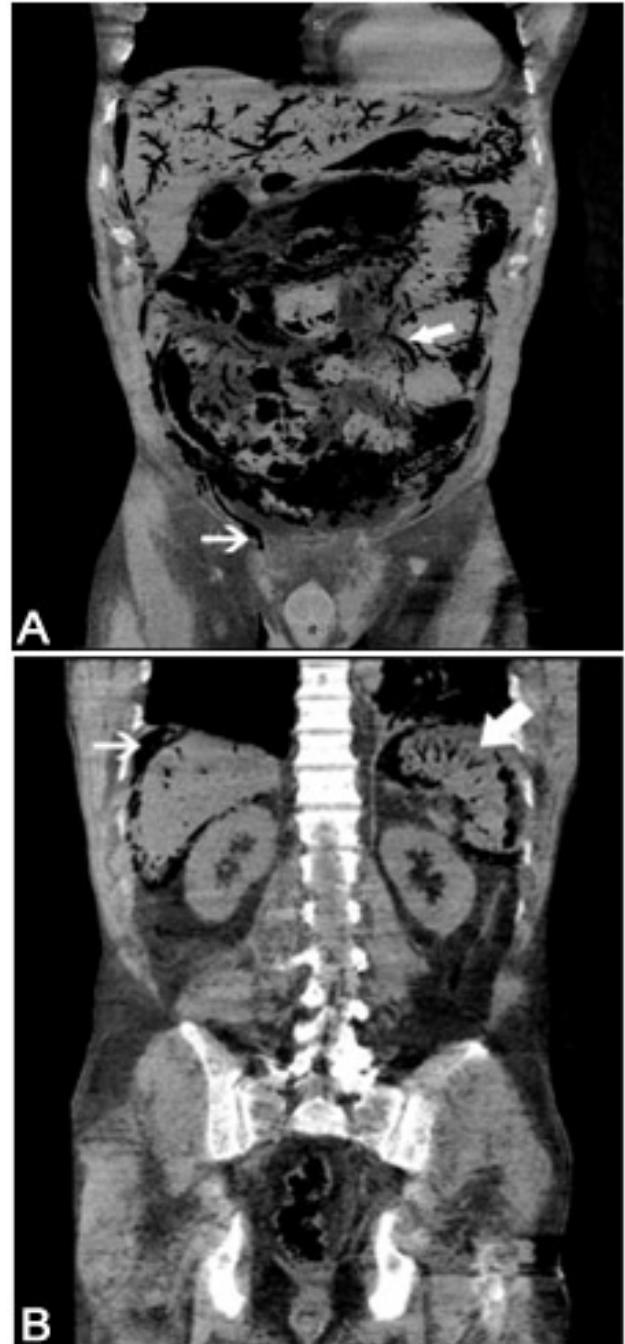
A. Computed tomography scan of the abdomen with coronal reconstruction. Portal venous gas, gas in wall bowel and mesenteric is observed. Mesenteric gas is observed in branched form towards the wall of the large intestine (thick arrow). Low attenuation path at right inguinal channel level corresponding to gas (thin arrow). B. Computed tomography images with coronal reconstruction. There are branching paths of low attenuation in spleen corresponding to pneumatosis (thick arrow). Collection of suprahepatic air corresponding to pneumoperitoneum (thin arrow).
